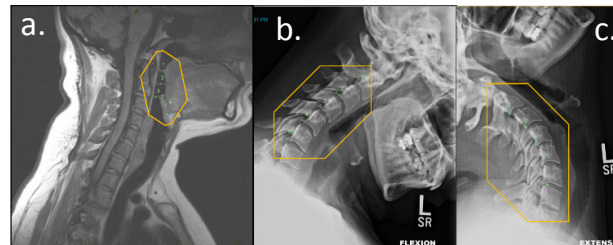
a. Example MRI airway measurement; b. Example flexion X-Ray; c. Example extension X-Ray; d. Table expressing headache and migraine prevalence in hypermobile patients with total cervical spine mobility less ($n=20$) or greater ($n=16$) than 1.25cm.
